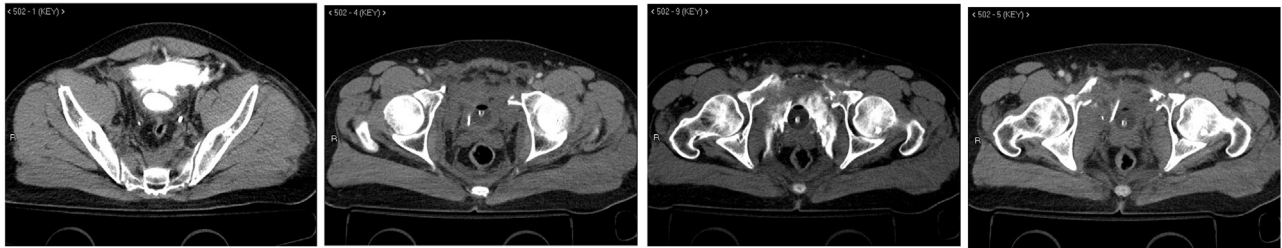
Axial views of a computed tomography scan showing multiple fractures of the pelvis and extravasation of contrast.
